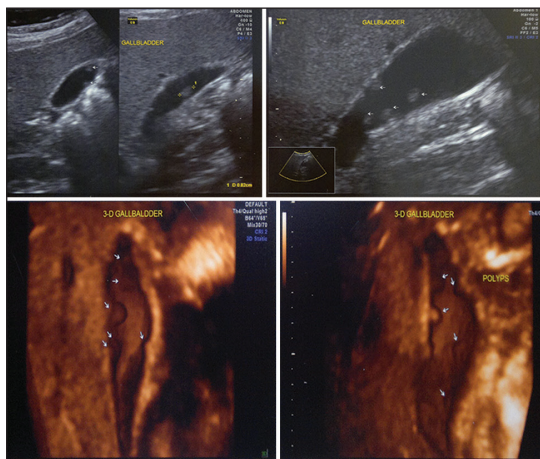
Ultrasonography depicting gallbladder polyps. Note the size and number
